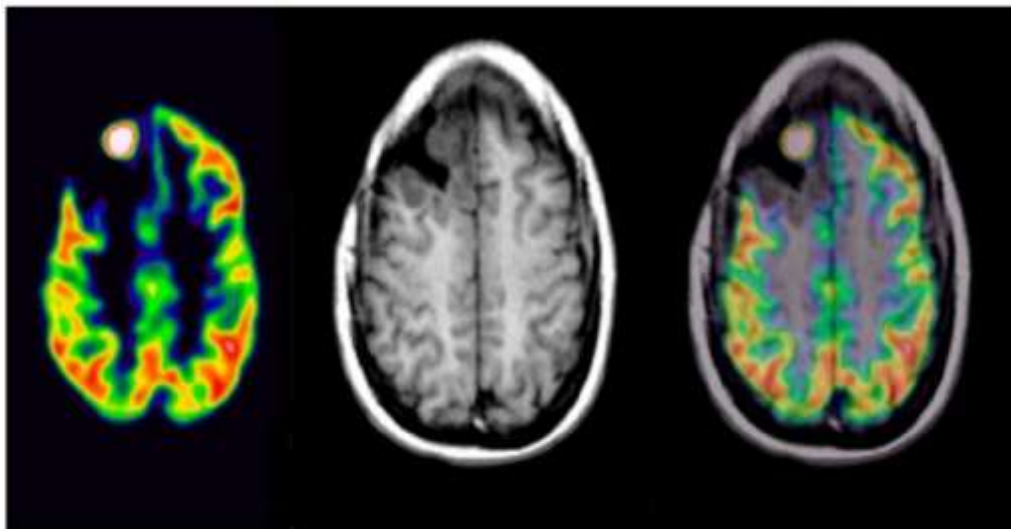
Left: Positron emission tomography (PET) scan with abnormality involving the right frontal lobe. Middle: Contrast magnetic resonance imaging (MRI) scan shows enhancement in the right frontal lobe. Right: There is a focal area of increased fluorodeoxyglucose (FDG) uptake involving the right frontal lobe consistent with a high-grade transformation and recurrence of tumor in the right frontal lobe 8 years after initial diagnosis and therapy. (Color version of figure is available online.)
